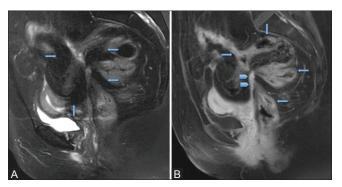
(A and B): (A) Sagittal T2-weighted image showing multiple small and large bowel loops tethered to each other in the pelvis (arrows). (B) Corresponding sagittal postcontrast T1-weighted image shows multiple tethered loops (arrows), with linear enhancement between the loops indicative of inter loop fistulization (arrowheads)
